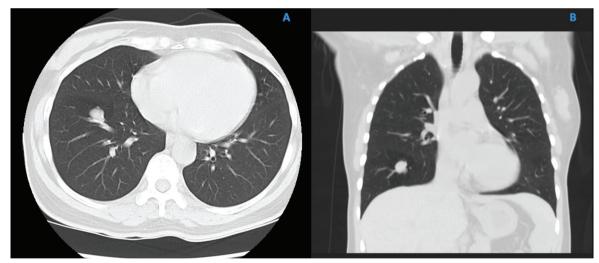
Patient's chest CT showed a 1.5-cm lobulated nodule in the right lower lobe. (A). Axial view. (B). Coronal view.
